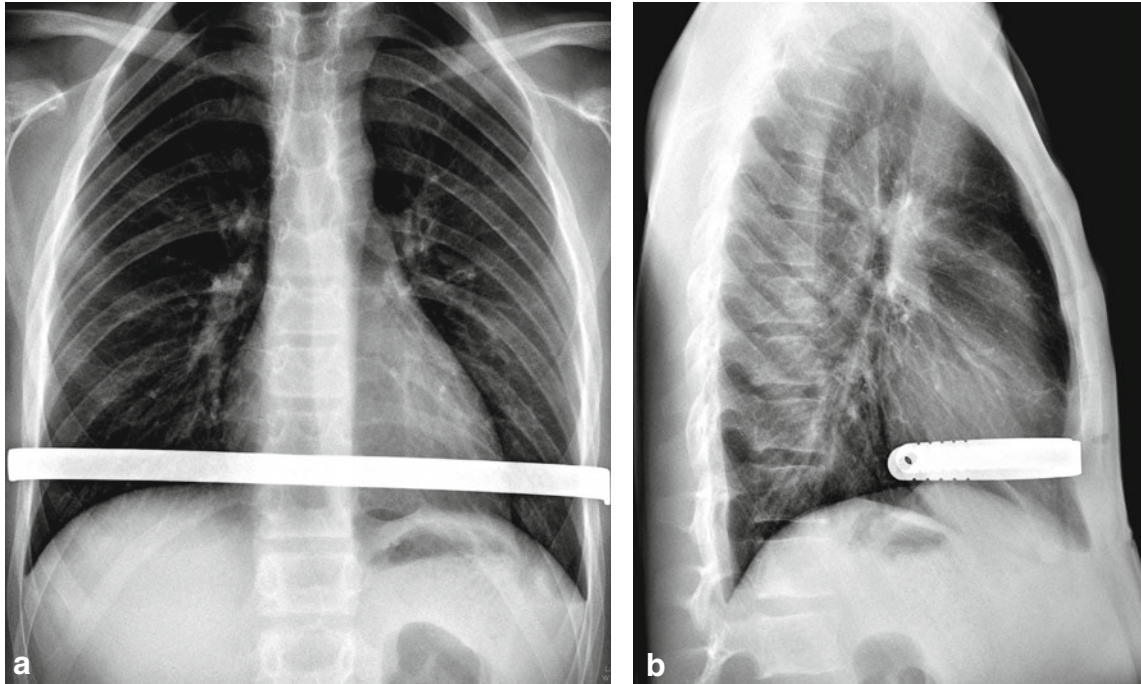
Postoperative X-rays with perfectly placed pectus bar, without hemothorax, hemorrhage, or pleural effusion
